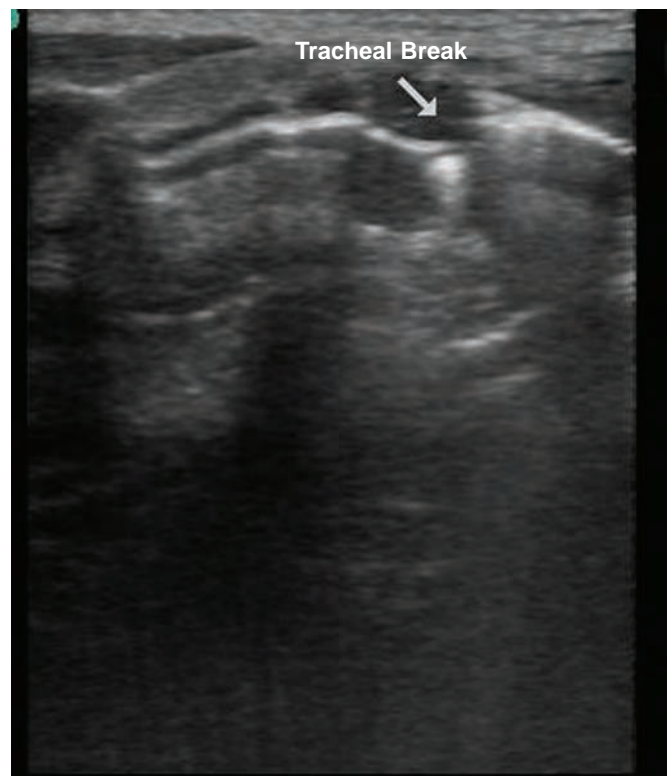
Ultrasound image (long-axis view) showing tracheal rent (Courtesy: Gupta *et al.* Eur J Trauma Emerg Surg 2012;38: 553-61)
